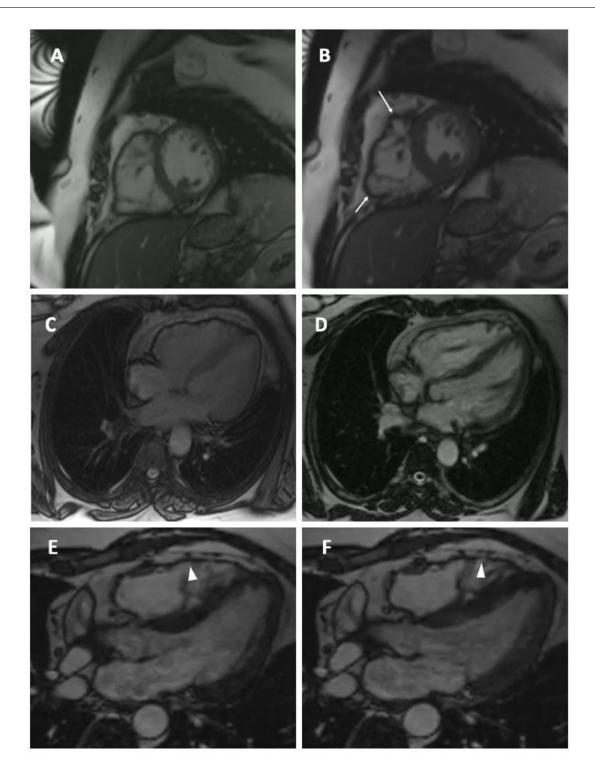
Cardiac MRI of our patient: (A) diastole; (B) systole: Short axis views showing a dilated RV with multiple aneurysms of the RV wall (Arrows). (C) 4 chamber view; (D-F) 5 chamber views showing RV dilatation and prominent RV trabeculations.
